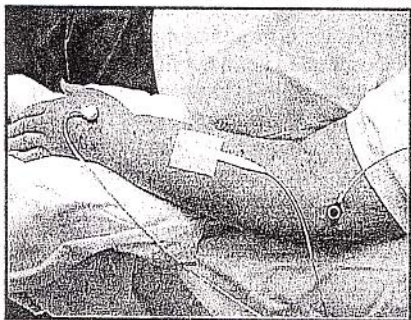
Laser-Doppler and TcPO₂ placement at standardized arm sites.
